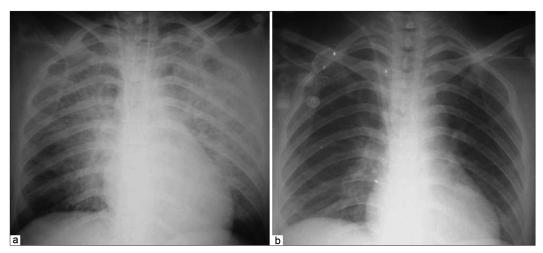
Chest radiography showing diffuse bilateral diffuse pulmonary infiltrates after aneurysmal rupture (a), which resolved 30 h later (b)
